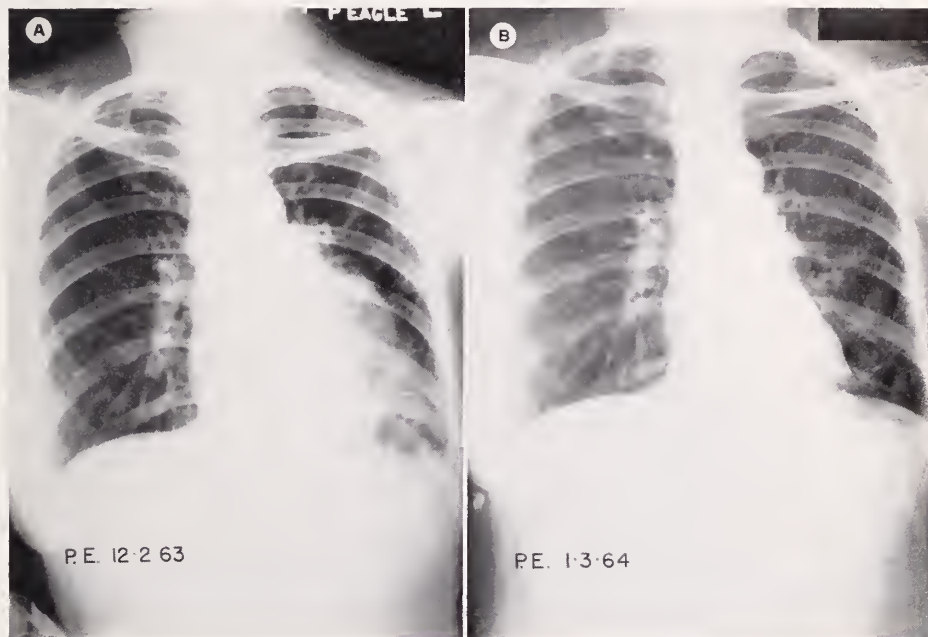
Serial chest x-rays showing regression of pleural effusion and pulmonary infiltration at left lung base, within one month after TP-MTX chemotherapy. (See case #2 for details.)
